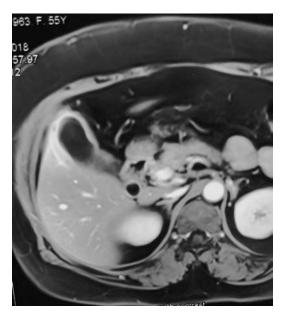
MRI shows diffuse thick-walled gall bladder (TWGB)—suggestive of xantho-granulomatous cholecystitis (XGC)
